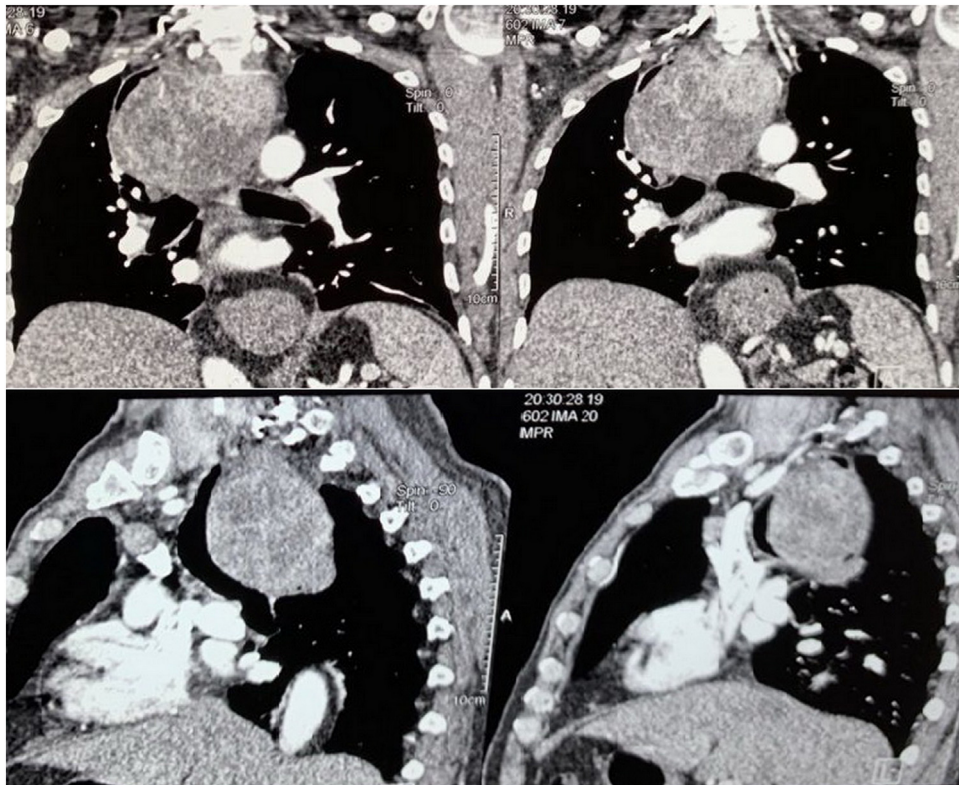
CT scan of the chest showing the enlarged thyroid gland extending to the posterior mediastinum and causing pressure and shifting of the trachea and the esophagus.
